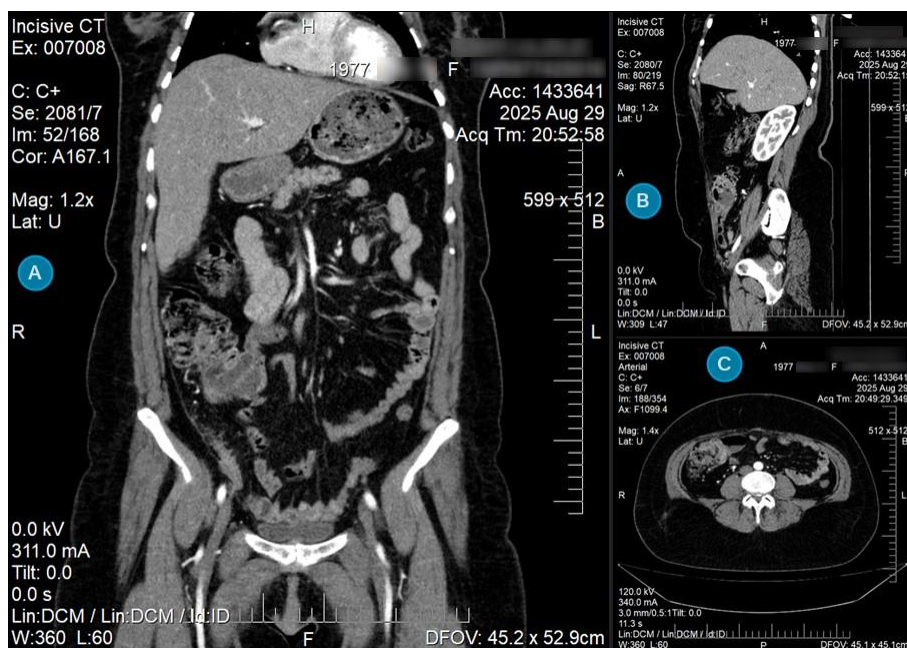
Contrast-enhanced abdominal CT (A) Coronal view, (B) Sagittal view, (C) Horizontal view
